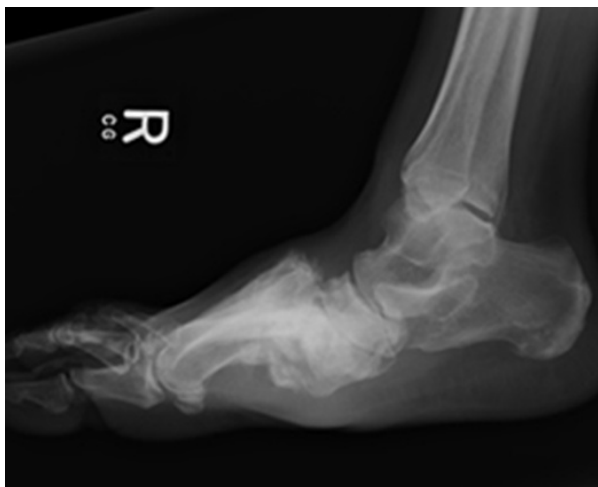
X-ray image of boney destruction from a Charcot event
